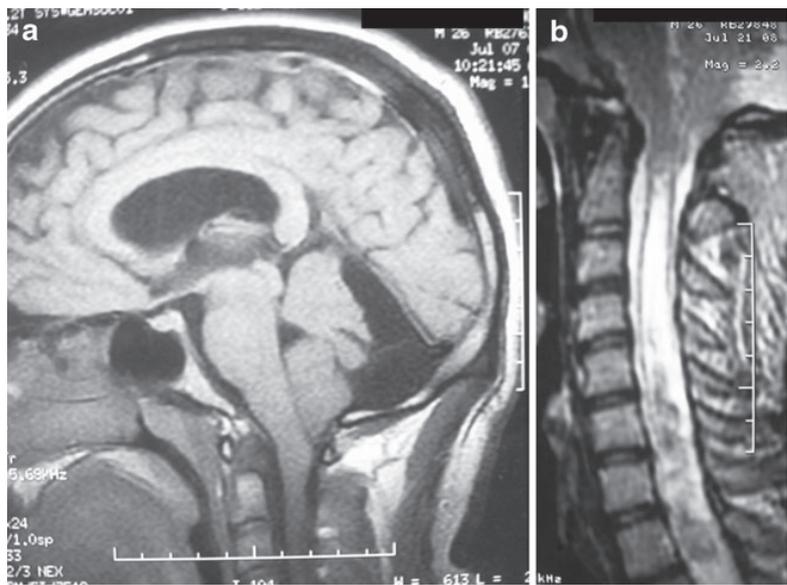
a Patient 6. T1 axial MRI of an hemispheric posterior fossa arachnoid cyst. Note the important mass effect compressing right cerebellar hemisphere. b Same patient, an T2 sagittal image showing a secondary CM1
